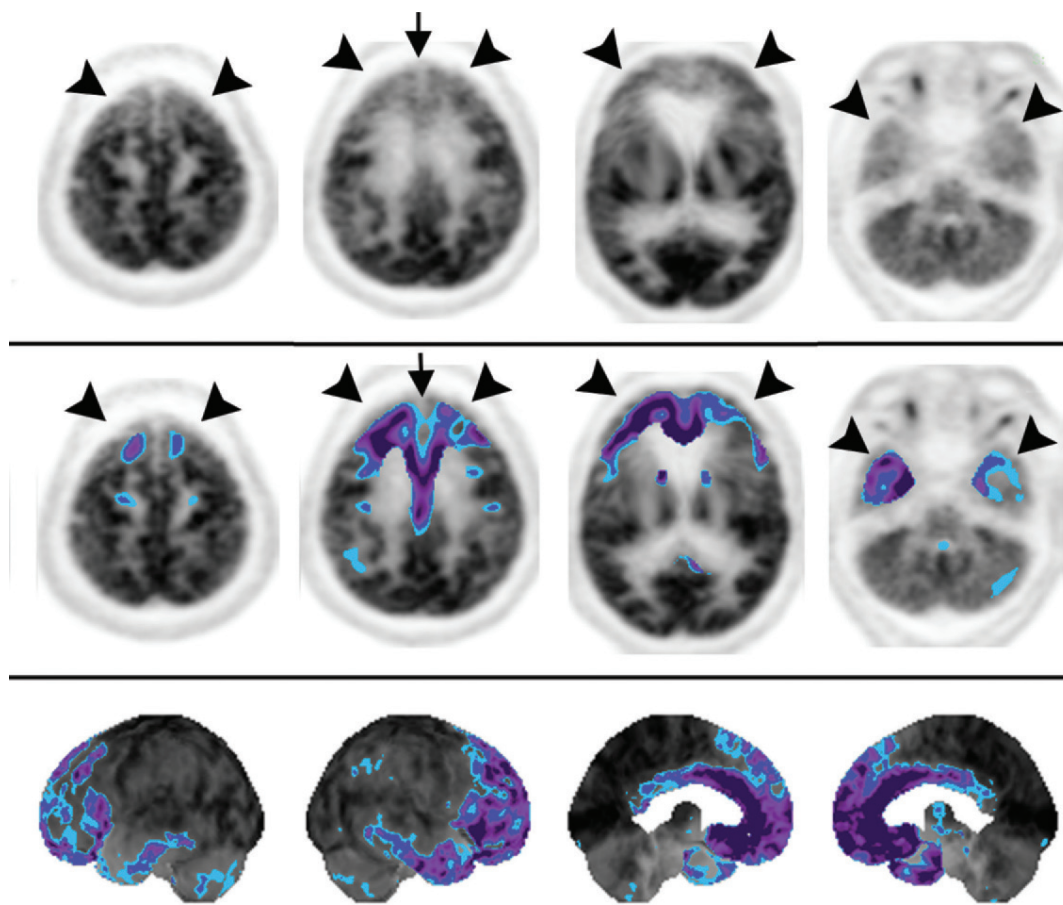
FTD. Axial gray-scale FDG PET images (top), corresponding statistical thresholding overlay images (middle), and 3D SSP images (bottom) (left to right: left lateral, right lateral, left medial, and right medial views) show moderate bilateral frontal and anterior temporal lobe hypometabolism (arrowheads) in a pattern that is characteristic of behavioral variant FTD. There is anterior cingulate gyral hypometabolism (arrows) as well as relatively preserved posterior cingulate–precuneus metabolism, findings that are best appreciated on the 3D SSP images. Blue = -2 SDs, purple = -3 SDs.
